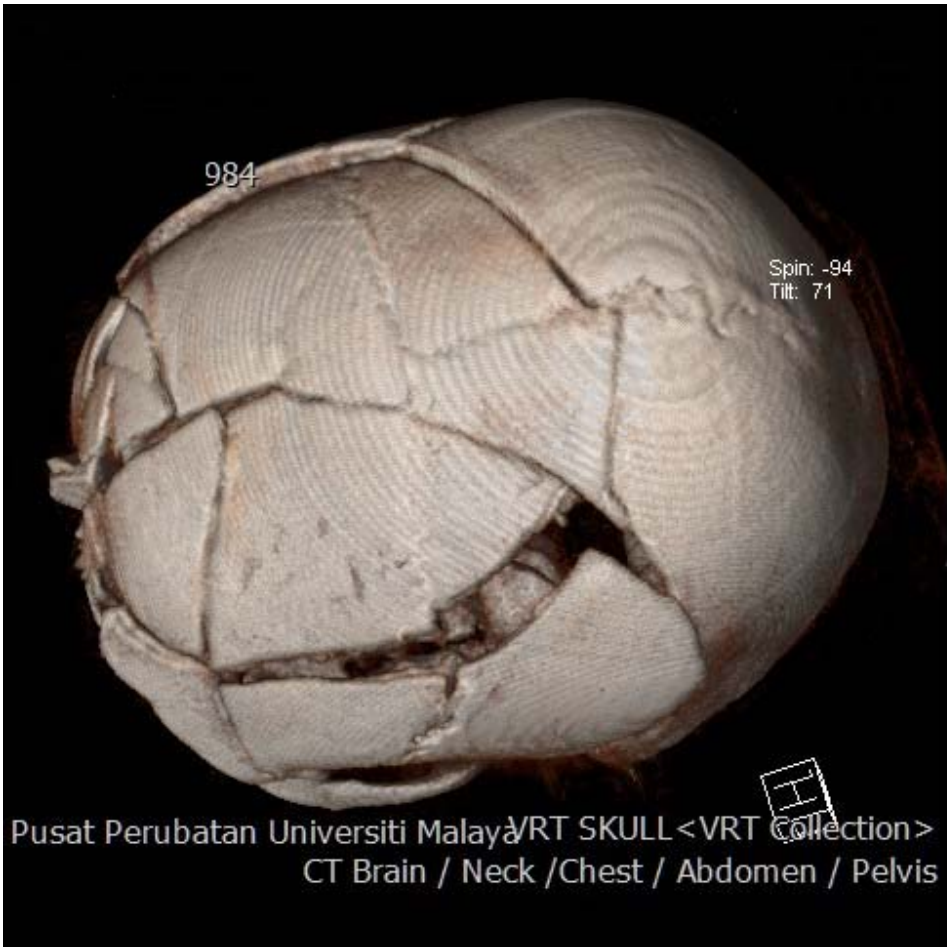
Extensive head injury sustained due to fall from height. Subarachnoid bleed, multiple contusions and cerebral oedema are seen in this axial computed tomography of the brain. There are also multiple skull fractures seen. The patient succumbed after 2 hours.
